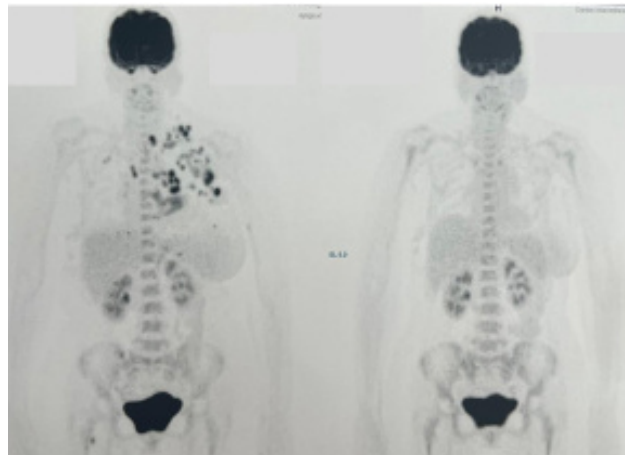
Comparative PET/CT images showing the achievement of complete metabolic remission.
